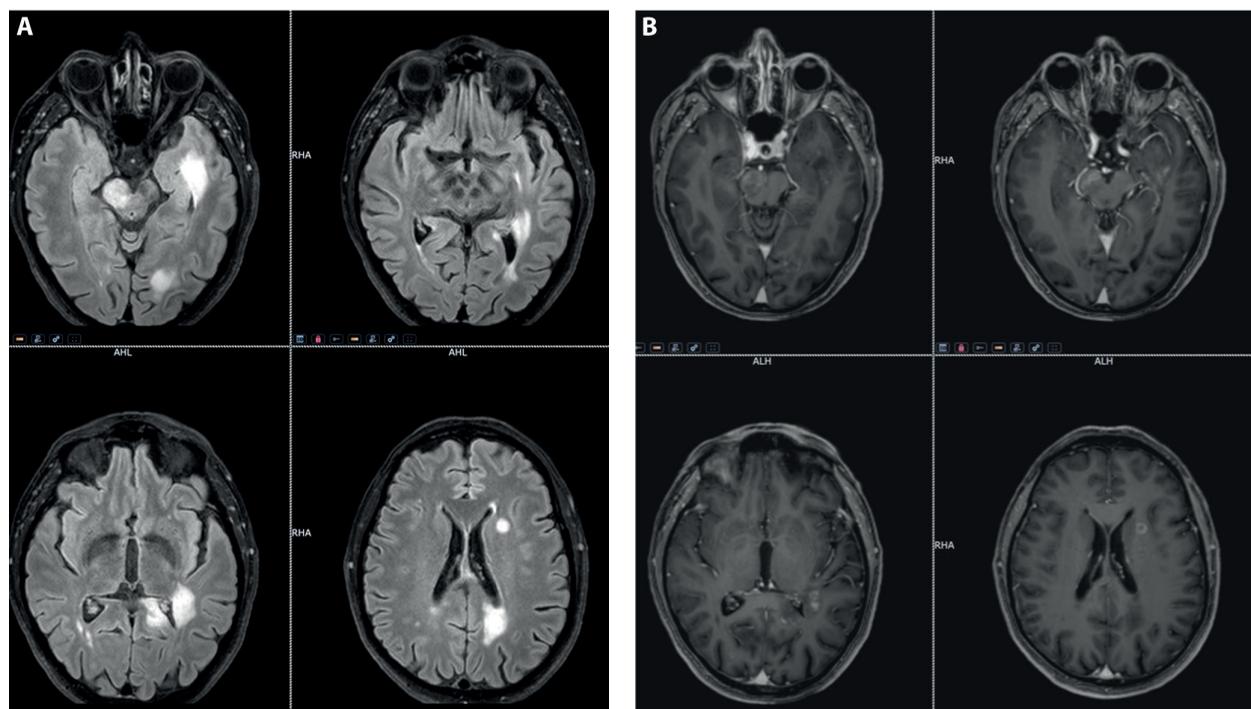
First brain Magnetic Resonance Imaging (MRI) findings.
